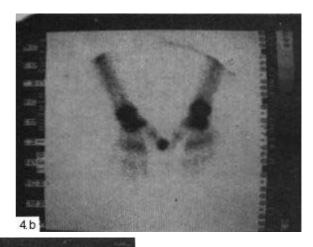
a) ^{99m}Tc-GP scan in a 4 year old-girl showing increased uptake in the right 1. phalanx, b) ^{99m}Tc-MDP image of the same patient and c) anterior ^{99m}Tc-GP image of thorax and abdomen. Note nonvisualization of left kidney. The diagnoses of left kidney aplasia was confirmed by ultrasonography.
